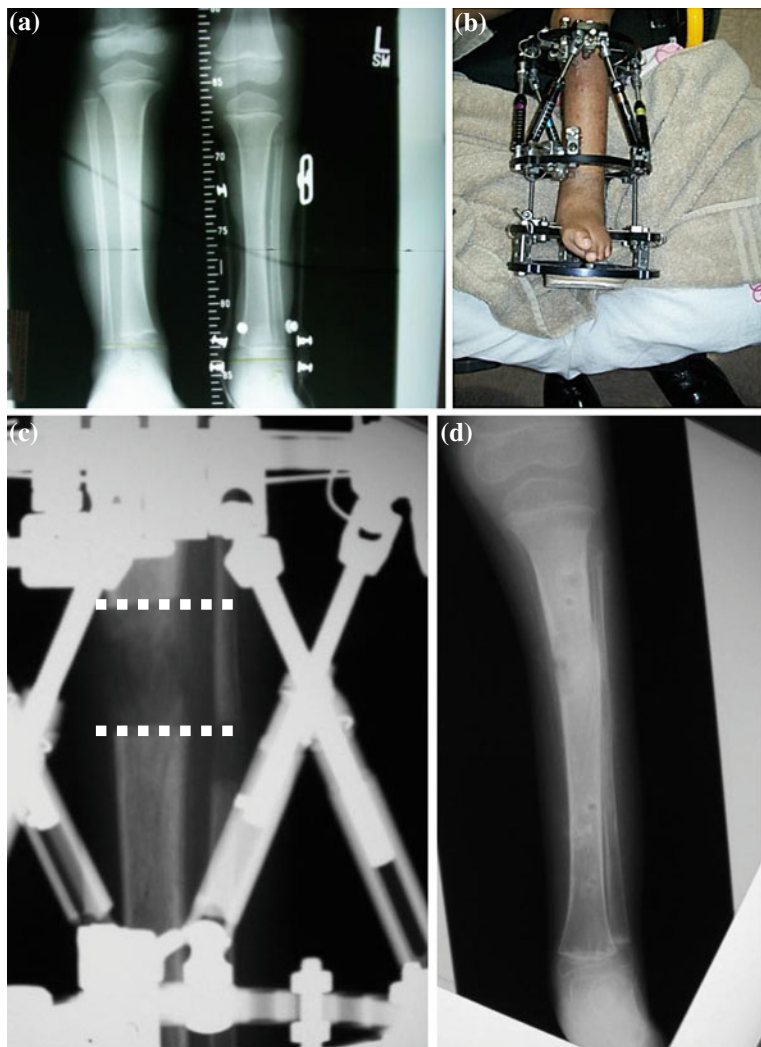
Distraction osteogenesis. (a) A 4-year-old girl with limb length discrepancy due to fibular hemimelia (*left side shorter*). (b) Lengthening was done by application of external fixator. (c) The bone was cut and then the soft callus was stretched to lengthen the bone (distance between two dotted line). The callus is then left to consolidate to hard bone. (d) Radiograph taken after removal of the fixator showing the new bone formation and increase length of the bone
